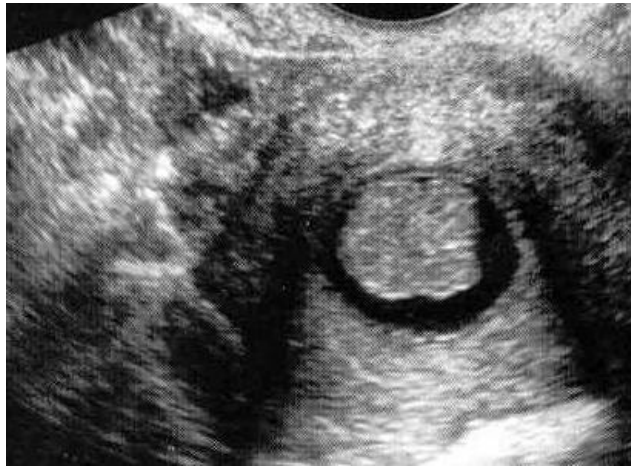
endometrial polyp outlined by fluid - (www.ultrasound-image.com)
